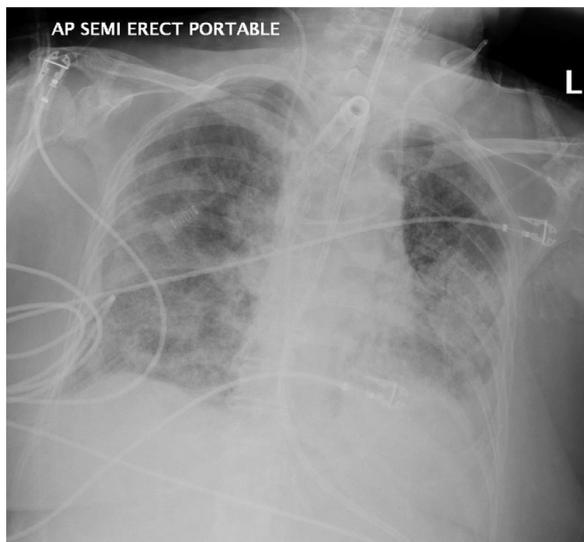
ARDS. (A) Frontal chest radiograph demonstrates diffuse coalescent pulmonary opacities in this patient with a tracheostomy tube in place.
